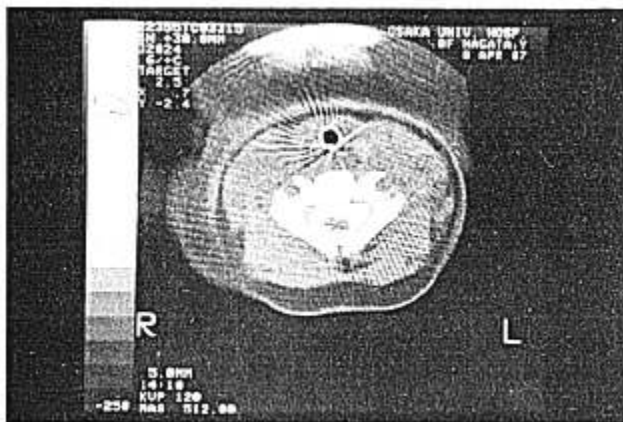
Transverse CT-scan of cervical myelography at C5 level. The artifact is observed to radiate from radiopaque marker of the tracheal tube.
